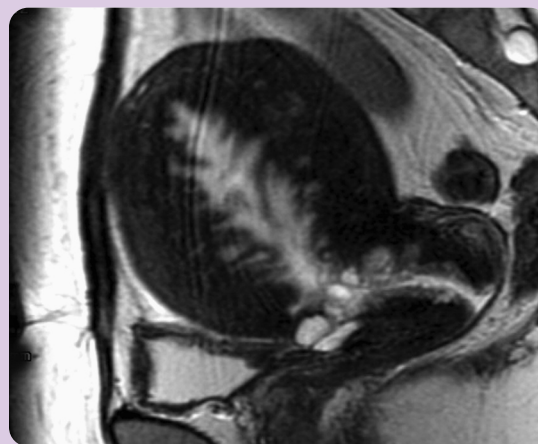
This sagittal T2-weighted FSE image depicts an enlarged uterus with diffuse adenomyosis. There is diffuse thickening of the junctional zone, and high-signal intensity fluid-filled glands are seen to extend from the endometrium.
